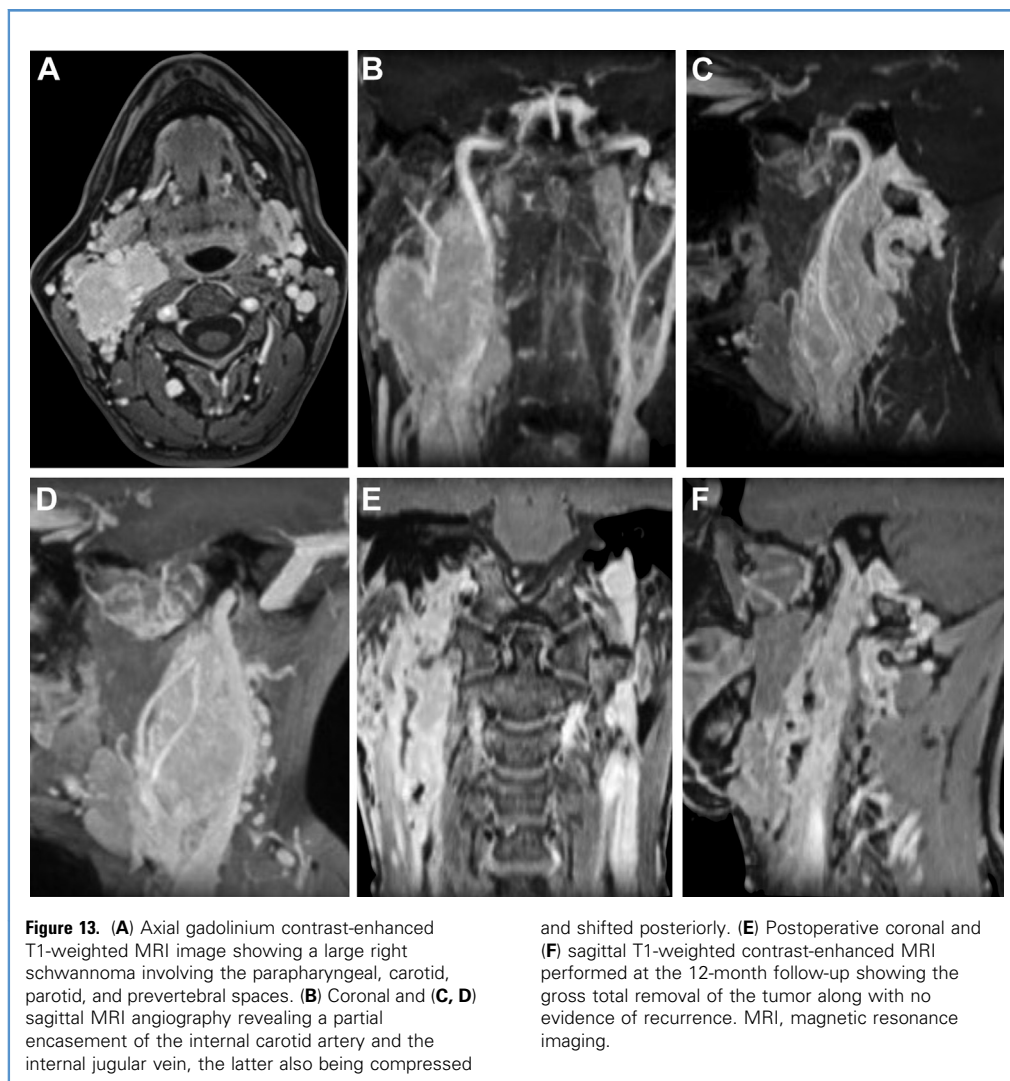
(A) Axial gadolinium contrast-enhanced T1-weighted MRI image showing a large right schwannoma involving the parapharyngeal, carotid, parotid, and prevertebral spaces. (B) Coronal and (C, D) sagittal MRI angiography revealing a partial encasement of the internal carotid artery and the internal jugular vein, the latter also being compressed
